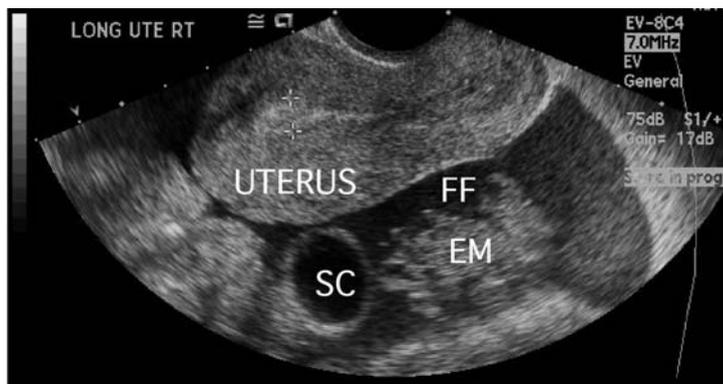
Transvaginal ultrasound demonstrating an ectopic pregnancy.
